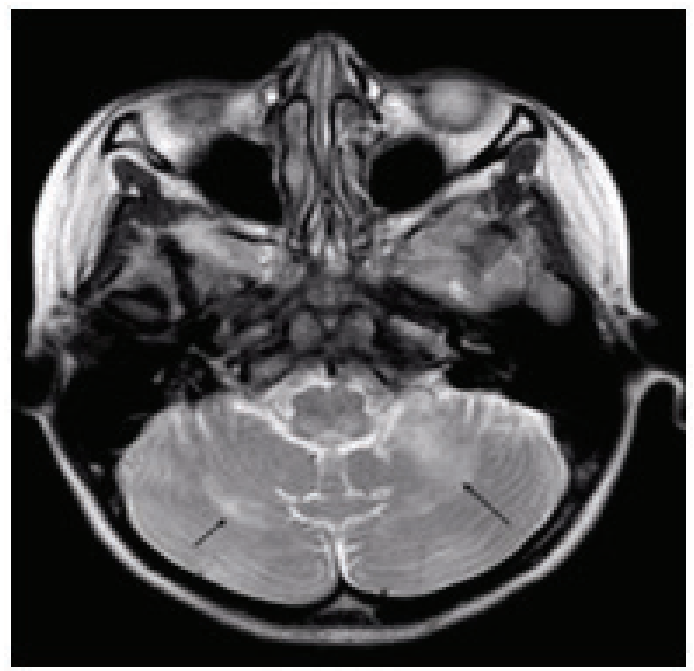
Axial T2-weighted image with hyperintensities in the cerebellar hemispheres.
